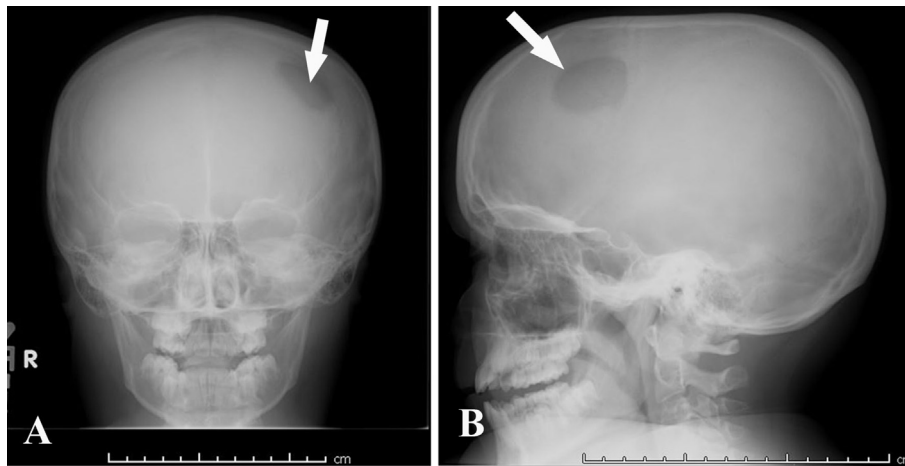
Frontal (A) and lateral (B) skull radiographs demonstrates a single "punched out" lucent lesion without sclerotic rim at the left frontal bone (arrow).
